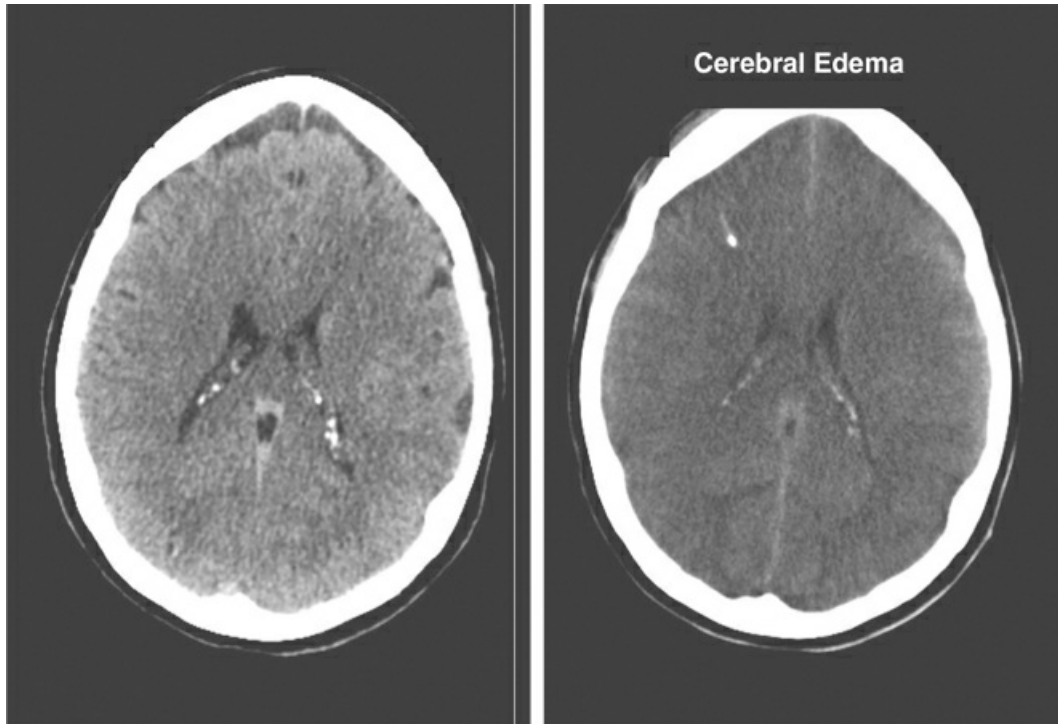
CT images of the head in a patient with acute liver failure, taken before (image on the left) and after (image on the right) the onset of cerebral edema. Note the effacement of sulci and loss of the grey-white interface in the image on the right. Images from Reference 6.
